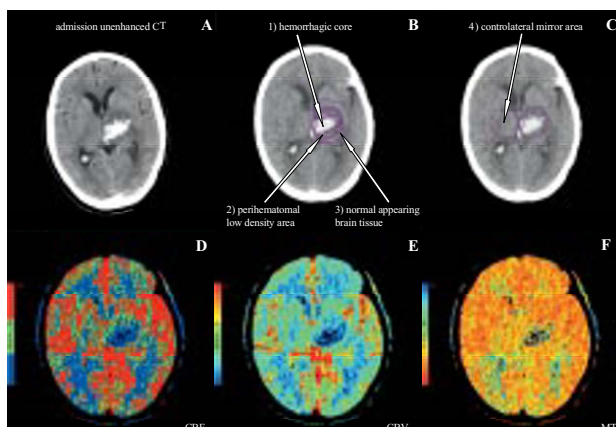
CT perfusion image of spontaneous intracerebral hemorrhage located in the left thalamus. *Image A* shows hematoma location on admission unenhanced CT scan. *Image B and C* show regions of interest placed within and around the hematoma and in the contralateral hemisphere on the baseline single slice CT scan. *Image D, E and F* depict maps of cerebral blood flow, cerebral blood volume and mean transit time.
